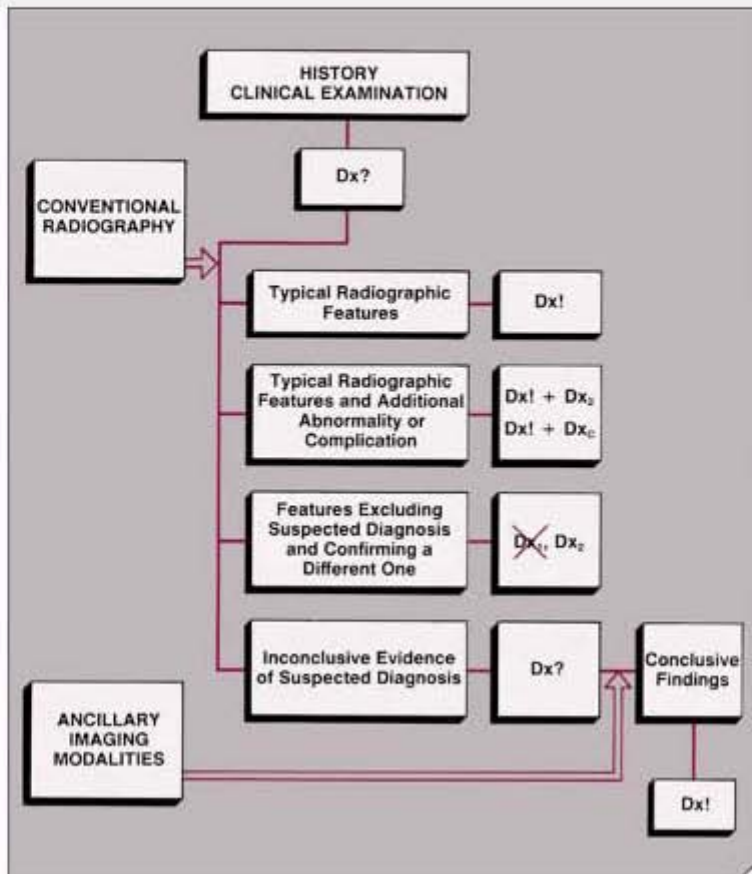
Cause of symptoms suspected. (A) and (B) From the information supplied by the referring physician, the radiologist may suspect the diagnosis ($Dx?$) and proceed with conventional radiographic studies. The results of the examination may confirm the suspected diagnosis ($Dx!$), reveal an additional abnormality ($Dx! + Dx_2$) or an unsuspected complication ($Dx! + Dx_c$), or exclude the suspected diagnosis and confirm a different one (symbol Dx_2). The studies may also show inconclusive evidence of the original suspected diagnosis, in which case ancillary imaging modalities, such as scintigraphy, conventional tomography, computed tomography, or magnetic resonance imaging, among others, are used.
